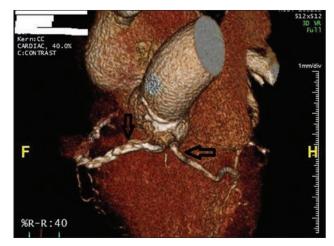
3D coronary CT scan reconstruction again demonstrating dual origins of the RCA (vertical arrow) and LM (horizontal arrow) from the right sinus of Valsalva.
